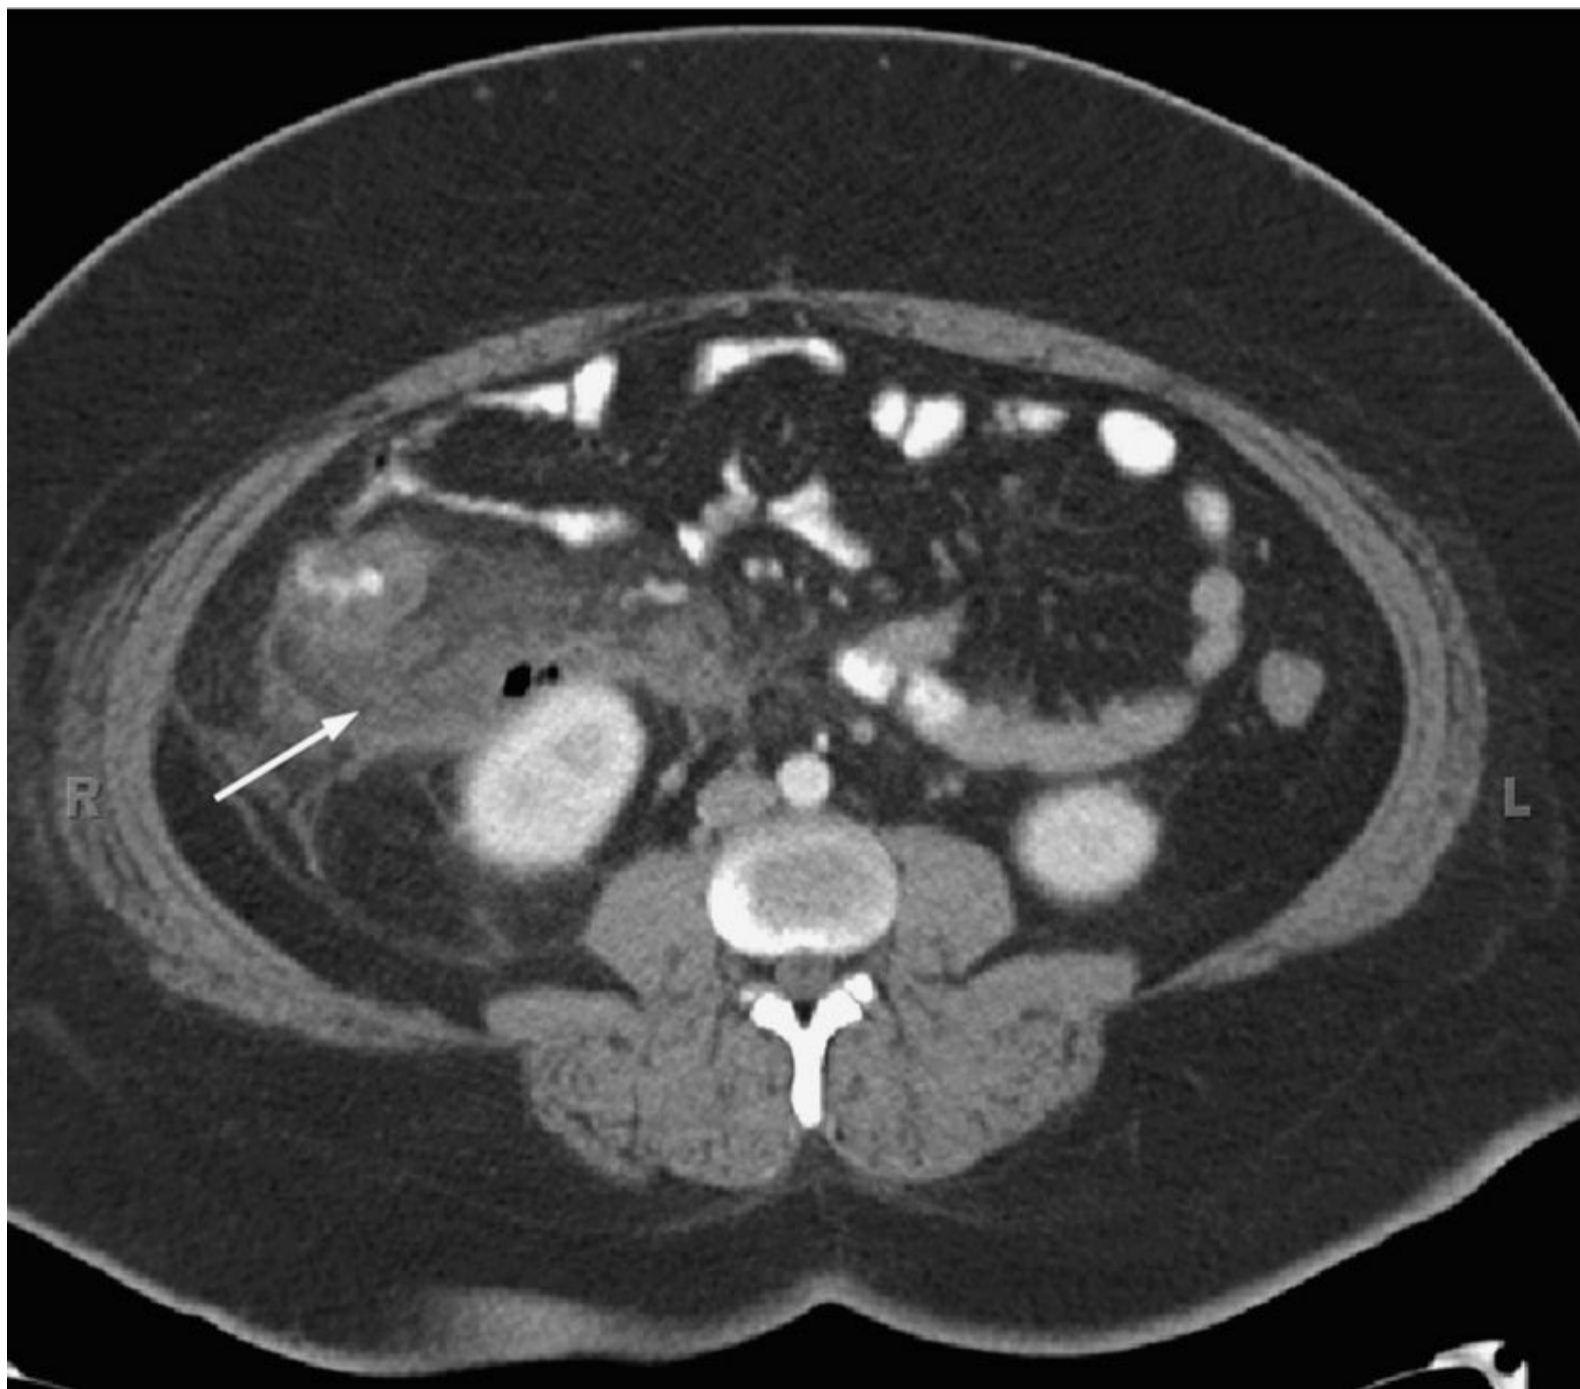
Computed tomography scan with oral and intravenous contrast of acute appendicitis. There are thickening of the wall of the appendix and periappendiceal stranding (*arrow*). (Reproduced, with permission, from Longo DL, Fauci AS, Kasper DL, et al, eds. *Harrison's Principles of Internal Medicine*. 18th ed. New York: McGraw-Hill; 2012.)
